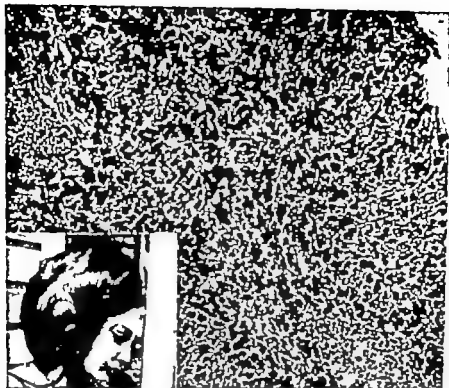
(No. 27325) Sclerosing osteogenic sarcoma arising from the posterior parietal region in a girl of 13. The inset in the lower left hand corner shows the appearance of the patient. She had noticed swelling and pain in this region for 8 months. Death occurred 3 months after excision of the tumor. Deep roentgen and radium therapy were without benefit.
